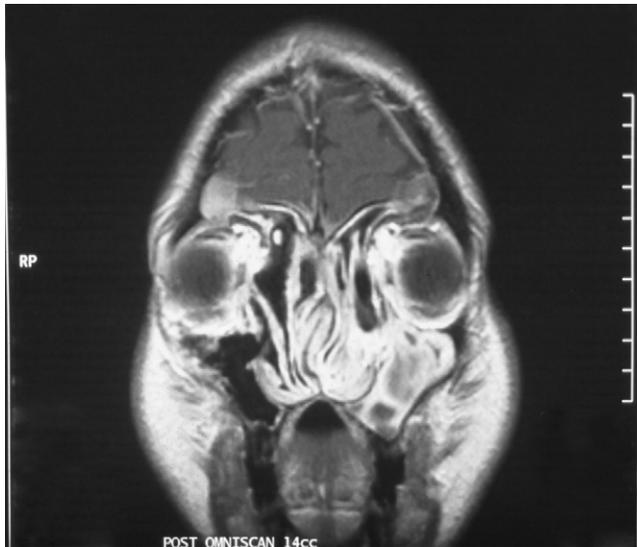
MR image of the same patient shown in Fig. 30-10. More soft tissue details can be viewed as compared to CT (Fig. 30-11).
